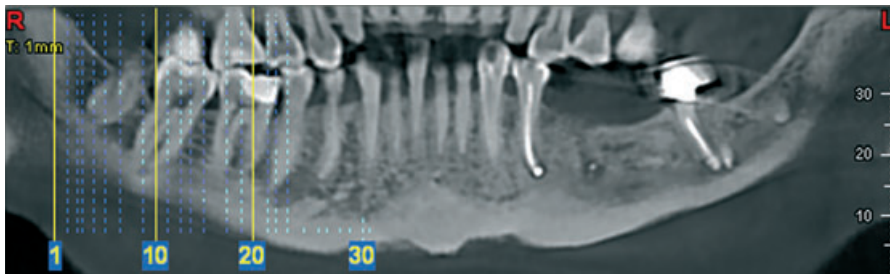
CBCT sagittal slice/cut through the filling material extruded from tooth 34.
